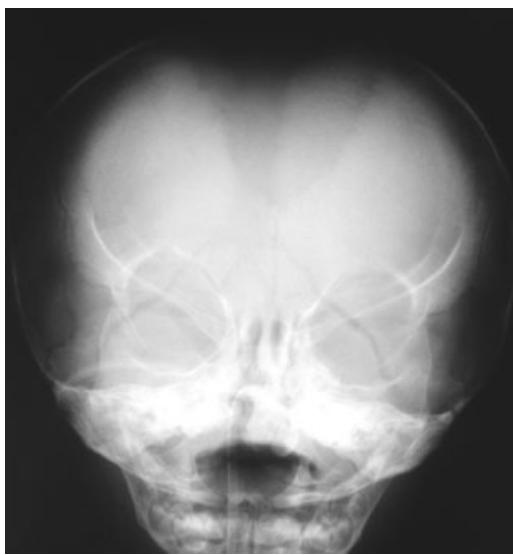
Cranial X-ray at birth showing an extremely large anterior fontanelle.
